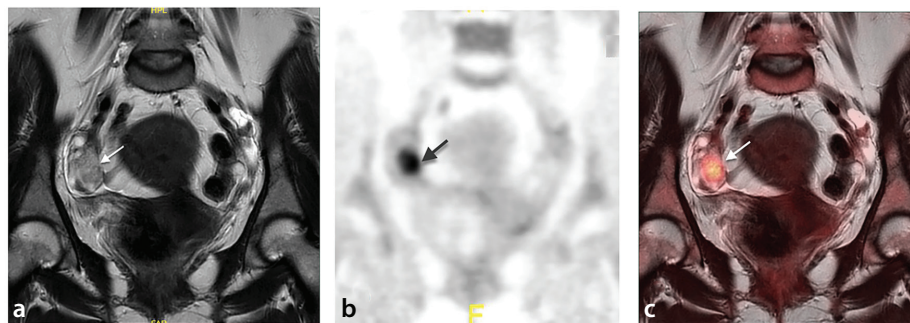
Corpus luteum. The coronal T2-weighted magnetic resonance image (MRI) (a) shows normal corpus luteum in the right ovary (arrow) along with ovarian follicles. The coronal positron emission tomography (PET) (b) and coronal fused PET/MRI (c) display focal fluorodeoxyglucose uptake in the corpus luteum (arrow), reflecting its metabolic activity.
